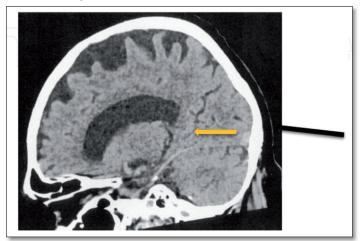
CT scan of extended INI patient at 5 years of treatment.
